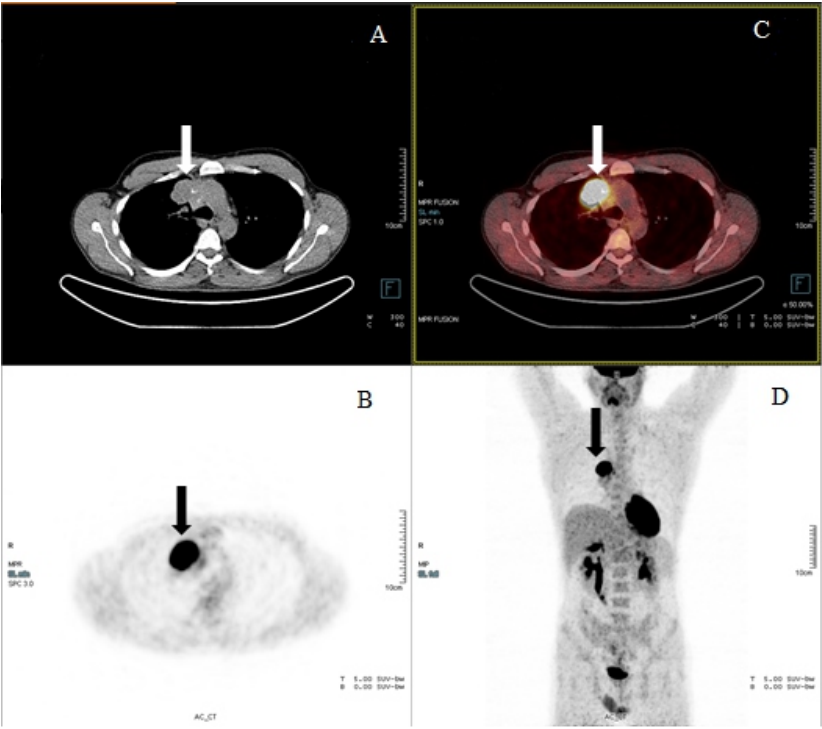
Initial ¹⁸F-FDG PET/CT scan in a patient with DLBCL; axial section on non-contrast, low-dose CT (A); PET (B); fusion PET/CT (C) and maximum intensity projection (MIP) (D); in which arrows point to a change in the mediastinum with intensively increased ¹⁸F-FDG accumulation, representing active disease.
